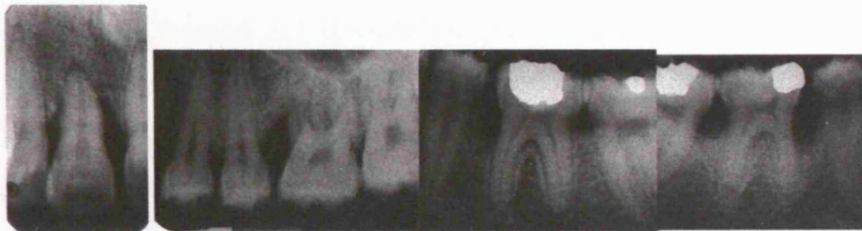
Long cone periapical radiographs showing the localised periodontal vertical defects of the patient described in chapter 5.2.2.
